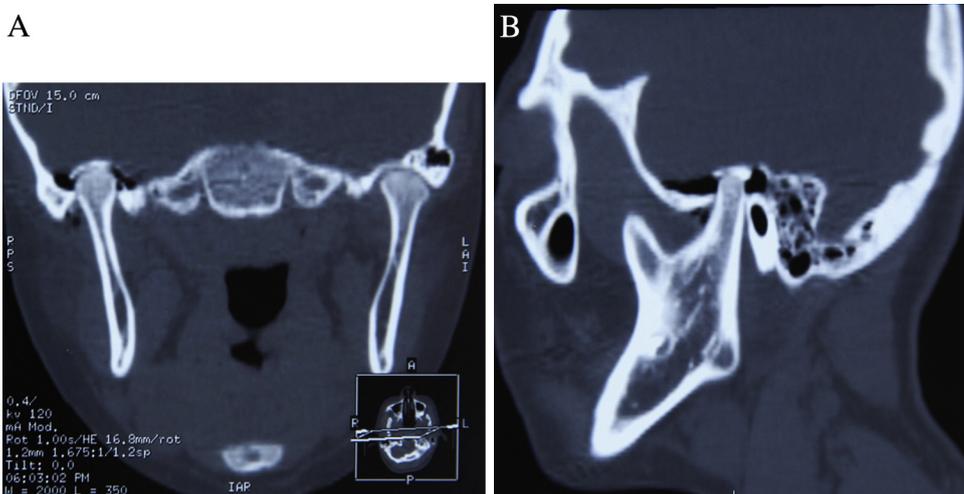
Preoperative CT imaging findings of case 1. (A) Coronal CT scan: the right-side condyle displaced superiorly into the skull. (B) Sagittal CT scan: the pneumocephalus at the fracture site.
